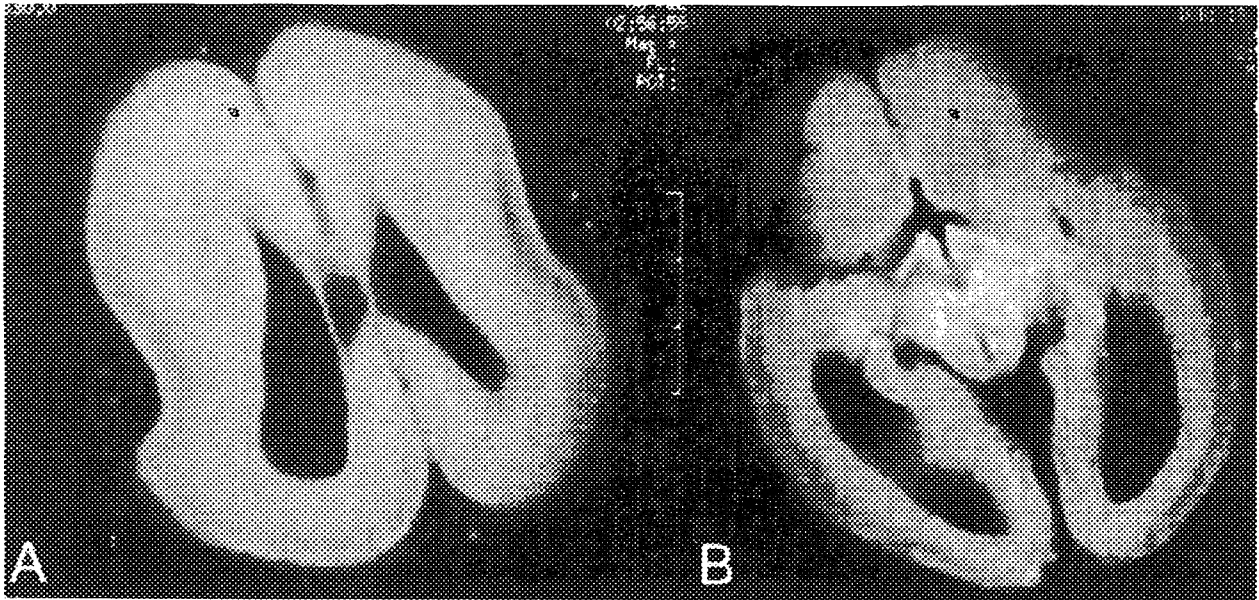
T*<sub>1</sub>-weighted magnetic resonance imaging brain scan (TR/TE = 8802/110 ms) depicting severe, grade 1 lissencephaly with diffuse agyria and no apparent gradient, and thick cortex. Interdigitations between the cortex and white matter were absent. (A) At the level of lateral ventricles: lateral ventricles were enlarged posteriorly. (B) At the level of midbrain: the opercula failed to fold over the insula.
